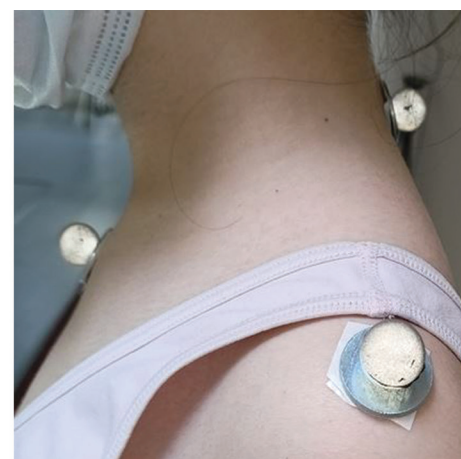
Appearance of reflective markers with a 16 mm diameter and a metal base for radiographical visualization
